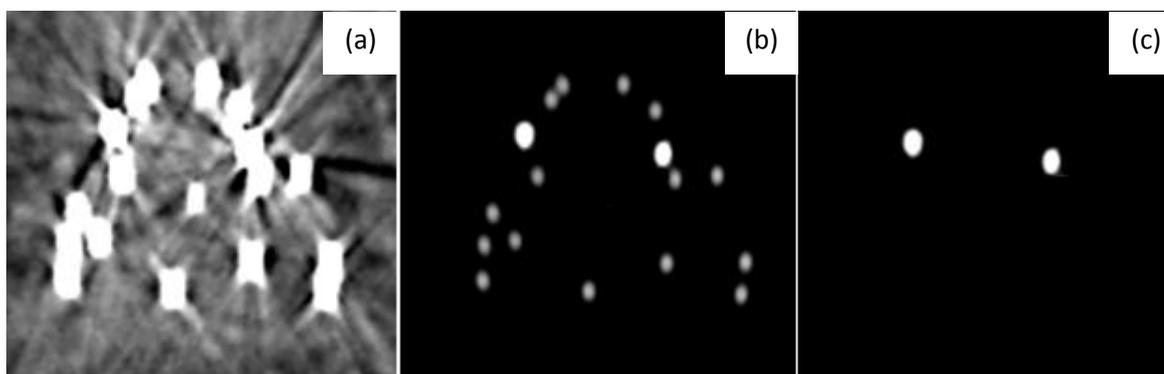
CT level and window settings to emphasise different features in acquired data (a) default, level 40, window -200 – 1600 HU, (b) steel needle, level 3700, window 2000 – 5400 HU, (c) gold seeds, level 13000, window 5000 – 21000 HU.
